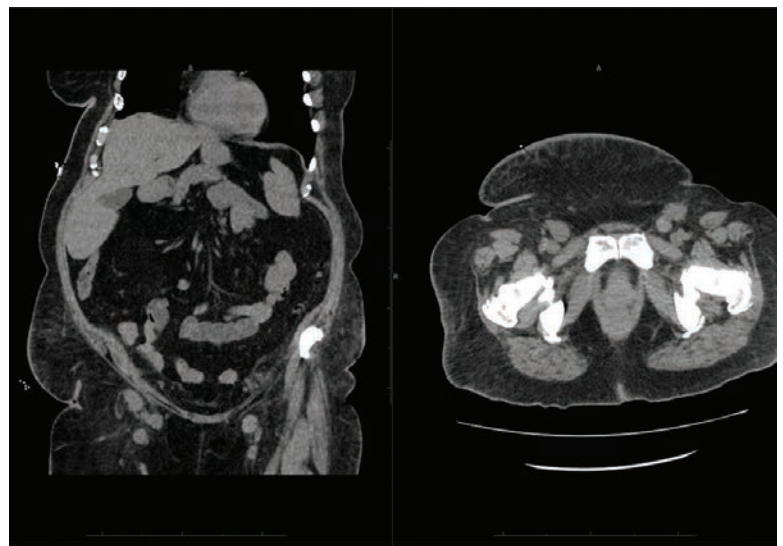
Computed tomography shows several enlarged lymph nodes within the inguinal regions and iliac chains within the pelvis bilaterally.
